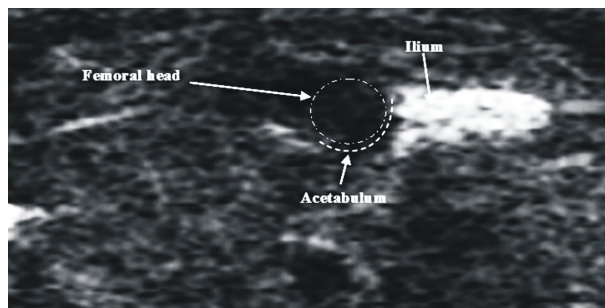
Ultrasound image of a 3-month-old fetus.
